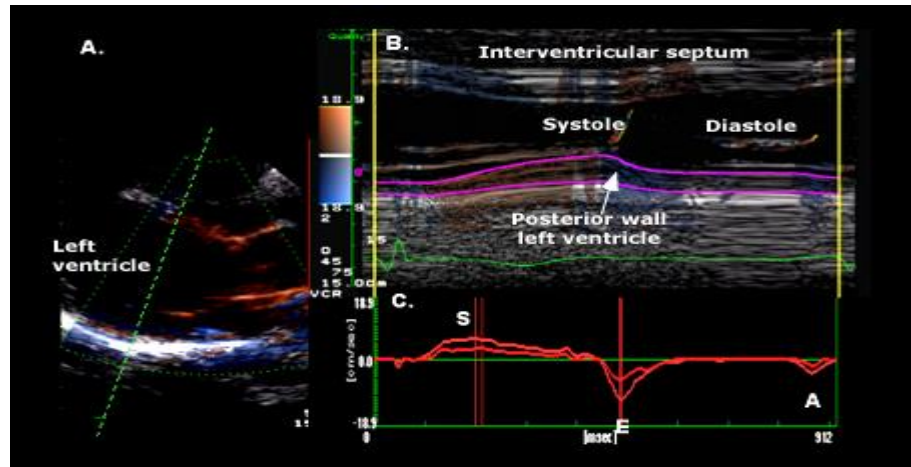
Tissue Doppler echocardiographic image of normal left ventricle of one of the patient from the control group (euthyroid group). S: peak systolic velocity; E: peak early diastolic velocity; A: peak atrial velocity.
